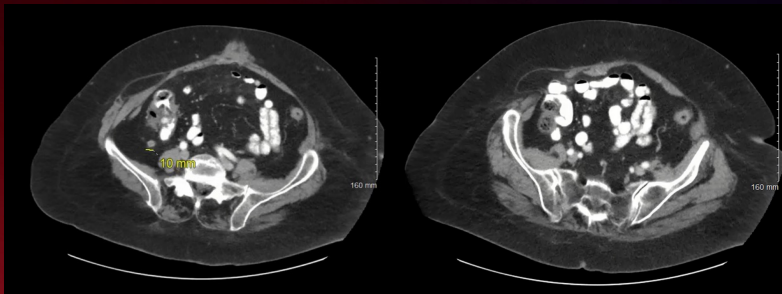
CT abdomen/pelvis with IV and PO contrast
